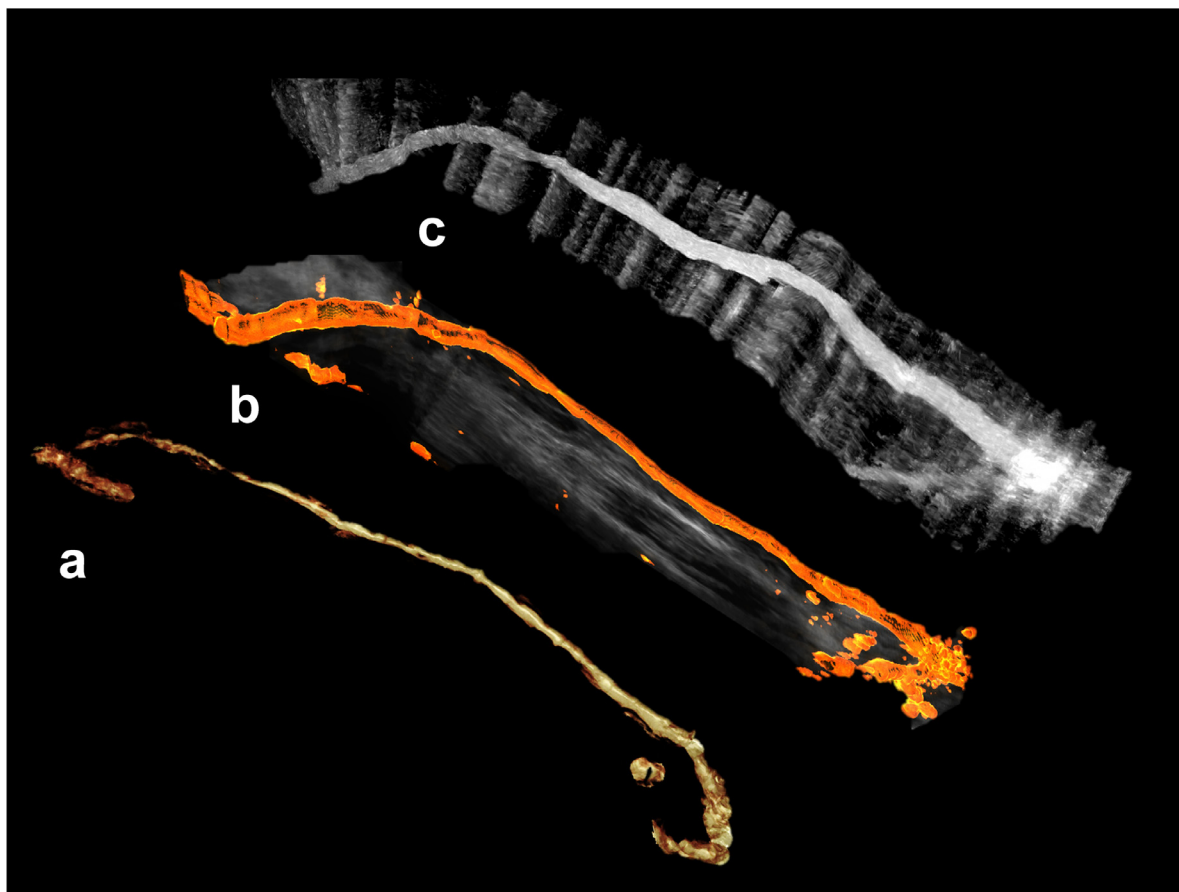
Comparison of 3-D tomographic ultrasound (tUS) reconstructions of the same arteriovenous fistula (AVF) based on different raw data. (a) 3-D tUS cropped image of the AVF based on B-mode data. (b) 3-D tUS image of the AVF based on power Doppler data. (c) 3-D tUS image of the AVF based on B-flow data (digital flow technique).
